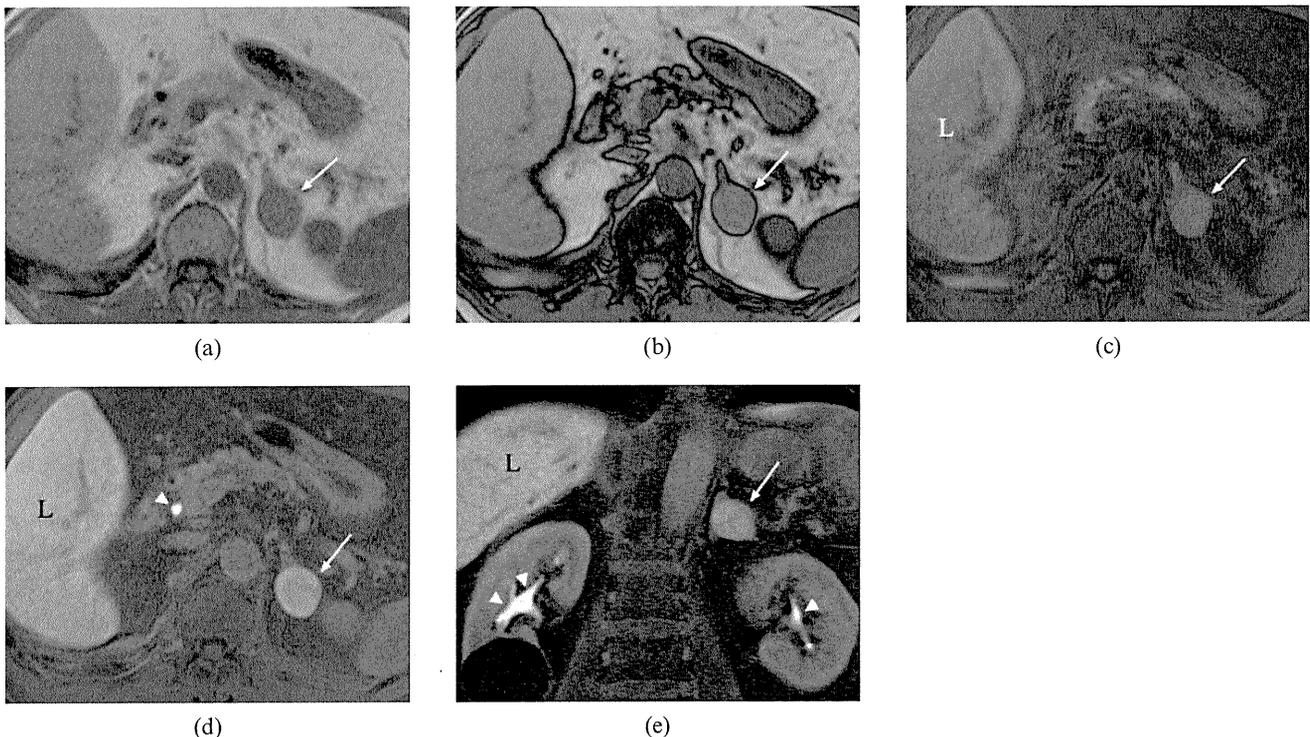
On (a) in- and (b) opposed-phase T_1 weighted gradient recalled echo MRI, no signal drop of the left adrenal nodule is demonstrated (arrows in a,b), which suggests a poor fatty component within the lesion. Compared with a (c) pre-contrast fat-suppressed T_1 weighted image, (d,e) the lesion is depicted as a homogeneously hyperintense nodule as well as hepatic parenchyma in the hepatobiliary phase 20 min after Gd-EOB-DTPA administration (arrows in c–e), which suggests the uptake of Gd-EOB-DTPA within the tumour (L, liver). Note high signal intensity in the common bile duct (arrowhead in d) and bilateral renal pelves (arrowheads in e), which represents contrast material excreted in the bile and urine, respectively.
